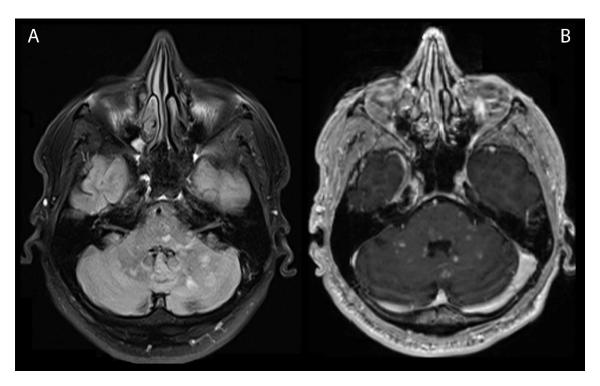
Pre-treatment Case 1, Axial T2-weighted FLAIR brain MRI scan obtained in a 3T scanner at the time of diagnosis before treatment onset. A. The image shows numerous hyperintense punctiform lesions measuring <3 mm in diameter ("salt and pepper sign"), predominantly in the infratentorial region (affecting the middle cerebellar peduncles and pons). B. Homogeneous gadolinium enhancement in all punctiform lesions (post-gadolinium T1w).
